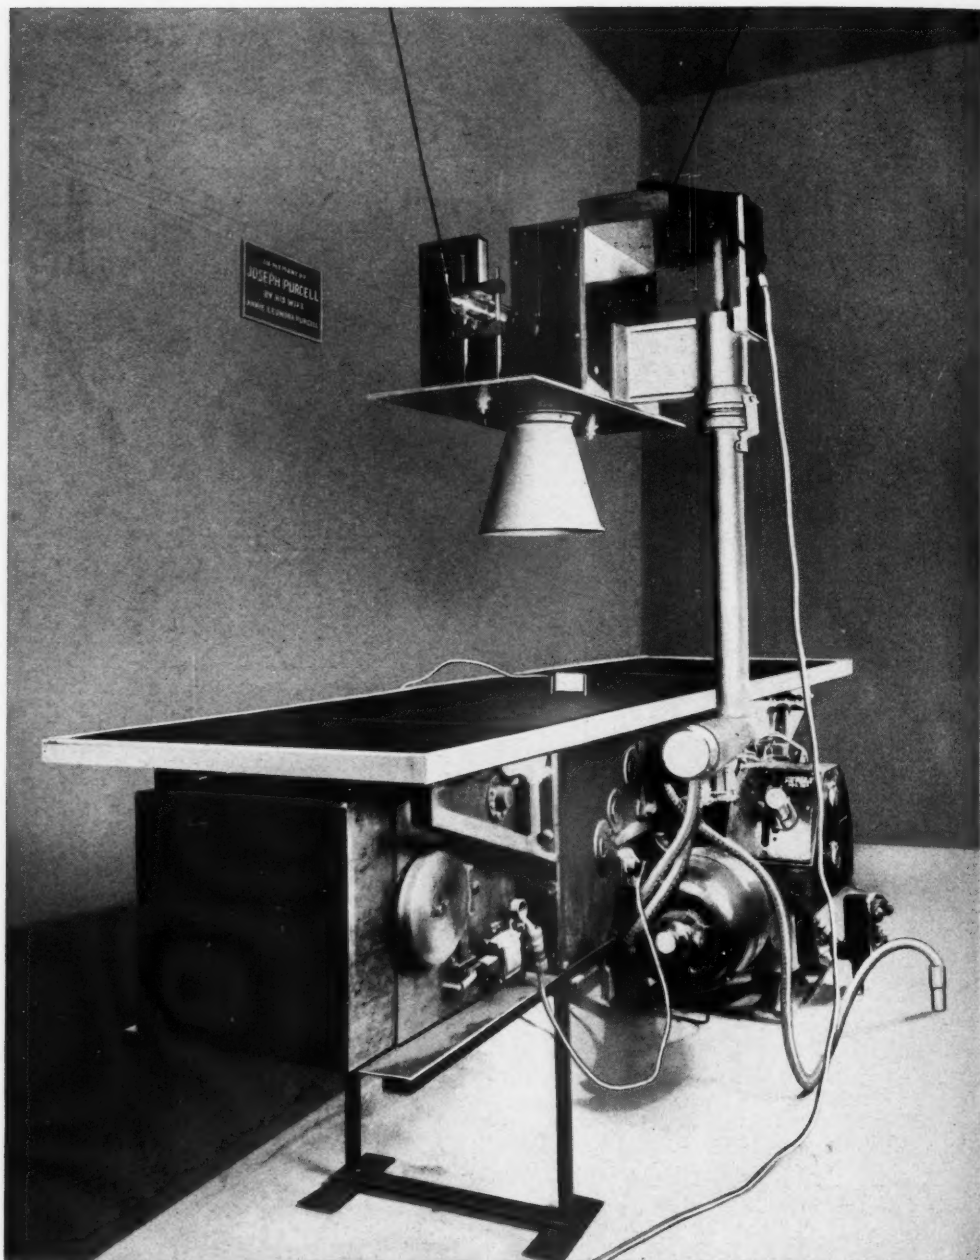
The roentgenocinematographic apparatus closed and ready for action. The tube is enclosed in a ray-proof box. The timing of the exposures is accomplished by a switch at the top of the tube stand which may be used to break either the secondary or primary current. The motor which drives the mechanical parts is observed in the foreground, and just behind this is a speed-changing device similar in size and shape to a gear shift on an automobile, which enables us to make a continuous roentgenographic film at various rates of speed.
